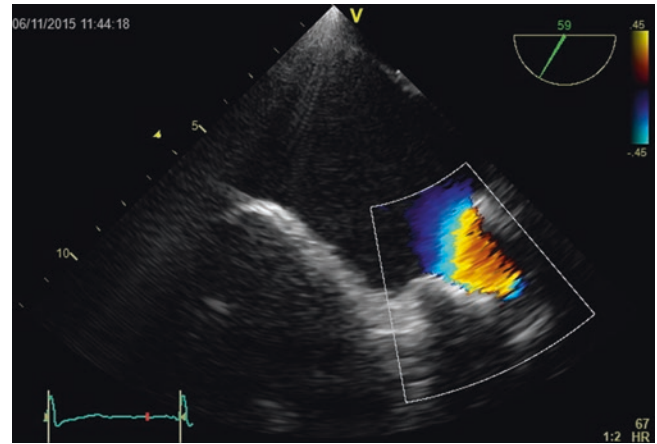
Transoesophageal echocardiography shows normal diastolic TrV inflow and absent tricuspid regurgitation
